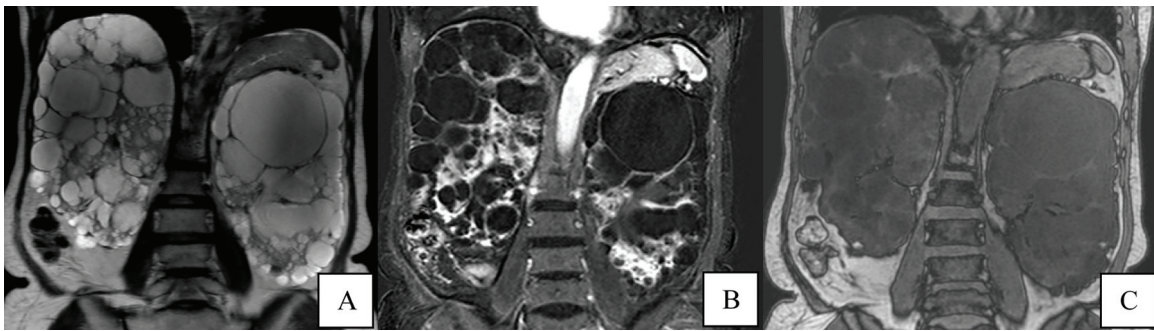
Coronal sshT2-weighted MRI (A), THRIVE T1W post-gadolinium contrast-enhanced MRI (3rd phase) (B), and IDEAL (opposed phase) images (C) of a 68-year-old woman with autosomal dominant polycystic kidney disease with co-existing innumerable liver cysts.
